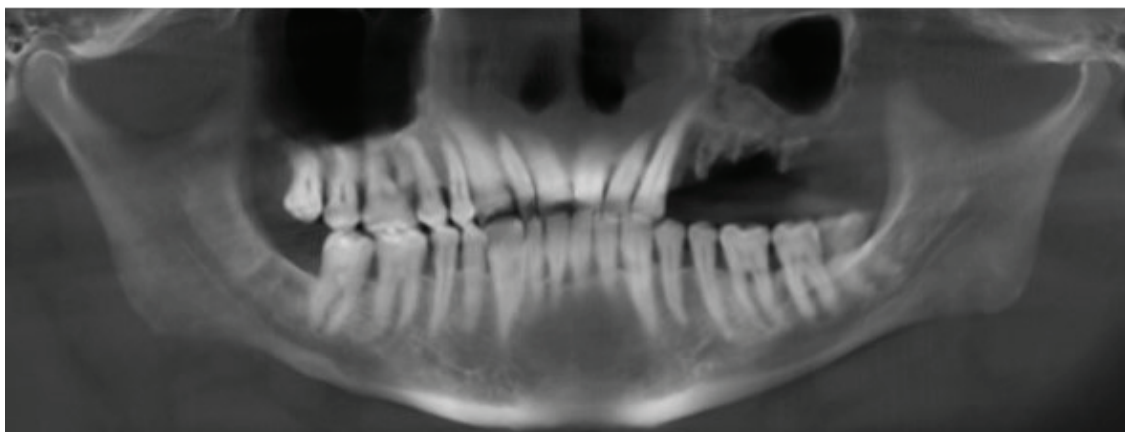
The Orthopantomogram reveals irregular alveolar bone with missing teeth in the 24-28 region with haziness in the left maxillary sinus
